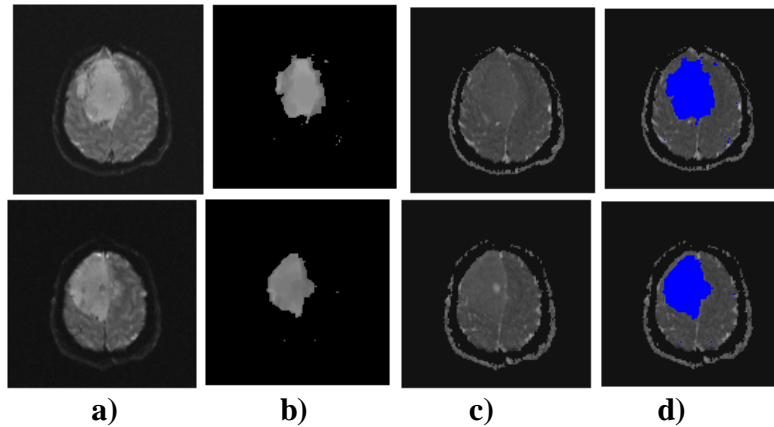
extracting tumor from MRI image and overlay it on second MRI image. a) registered image, b) extracted tumor from the registered image, c) original image, d) tumor overlaid on the original image.
